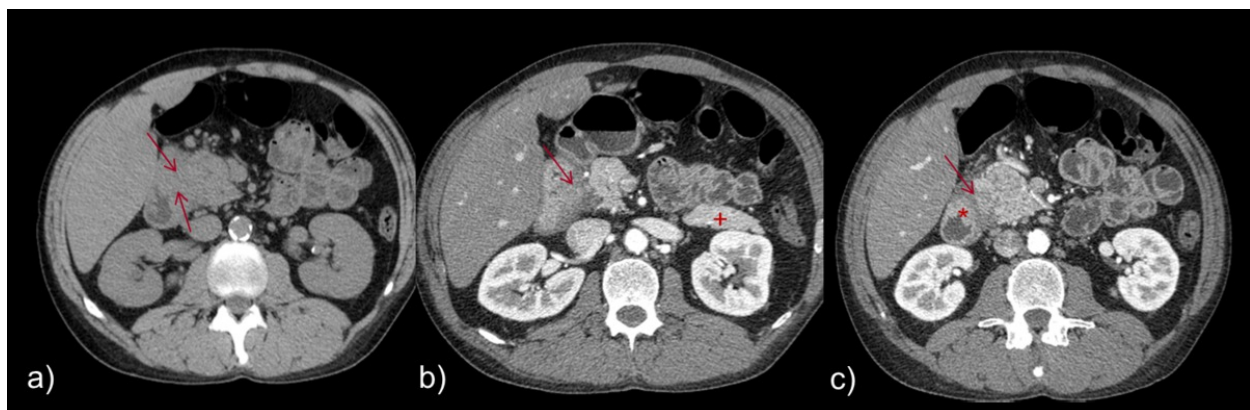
Unenhanced a) and enhanced axial CT images b) c) of a patient presenting with an ill-defined "sheet-like" soft-tissue mass within the pancreaticoduodenal groove, hypointense to the pancreatic parenchyma after iodinated contrast medium administration (arrows). There is not parenchymal atrophy or main pancreatic duct dilatation (+) and thickening of the duodenal wall can be observed (*).
